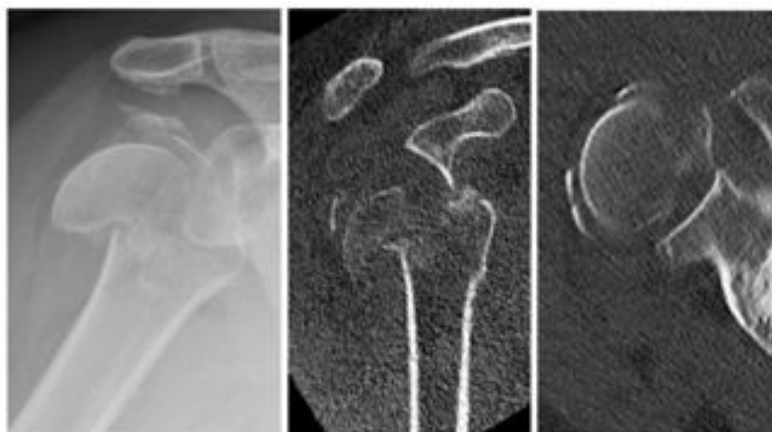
AP radiograph as well as coronal and axial CT images of patient 2's right shoulder demonstrating a posterior fracture dislocation of the humeral head.
